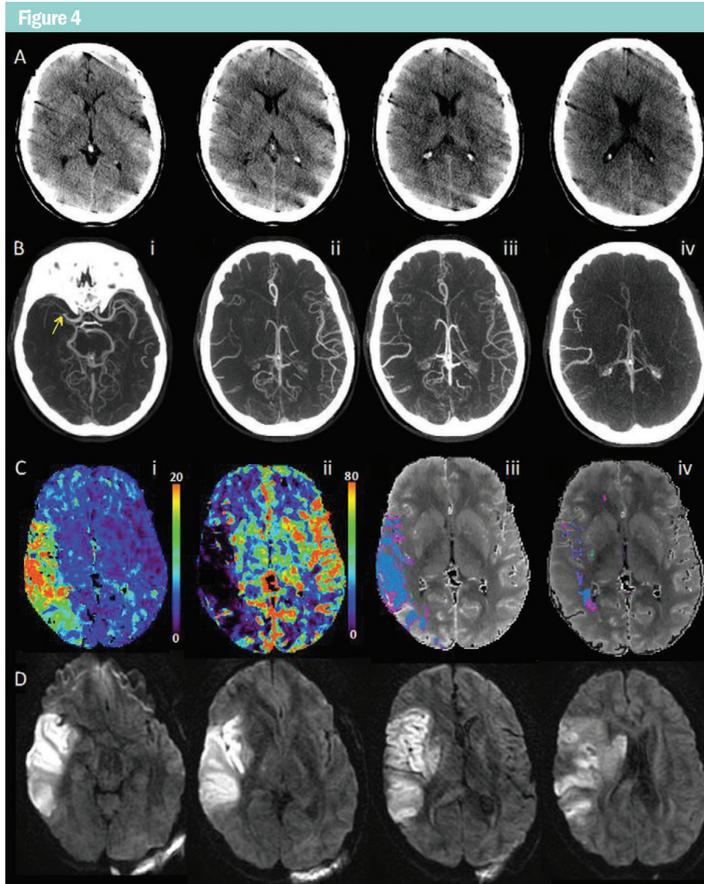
Multimodal CT imaging at 2 hours 51 minutes after symptom onset in a 47-year-old woman with NIHSS of 20 and right hemisphere symptoms. *A*, Unenhanced CT shows movement artifact; however, ASPECTS score was 7. *B*, A proximal right M1 MCA occlusion is seen (*i*). Multiphase CT angiography (three phases) maximum intensity projection images are shown (*ii*, *iii*, *iv*). Ptal arterial filling is modest, with delay of two phases and some regions indicating minimal filling when compared with the contralateral side, thus indicating that no treatment be performed. *C*, Perfusion CT Tmax and cerebral blood flow (CBF) maps (*i*, *ii*). Tissue with Tmax greater than 6 seconds (pink) is superimposed onto the CT perfusion average maps for both gray and white matter (*iii* and *iv*, respectively). CBF less than $10 \text{ mL}\cdot\text{min}^{-1}\cdot 100 \text{ g}^{-1}$ and less than $7 \text{ mL}\cdot\text{min}^{-1}\cdot 100 \text{ g}^{-1}$ for gray and white, respectively, is flooded in blue on the CT perfusion average maps (*iii*, *iv*). CBF-defined infarct core is 100 mL. A mismatch ratio (total Tmax hypoperfusion volume/total CBF infarct volume) of 1.7 and a large infarct core indicates that no treatment should be performed. Multiphase CT angiography and perfusion CT imaging are congruent for treatment decision. *D*, Diffusion MR images at 24 hours after admission show the final infarct as hyperintense.
